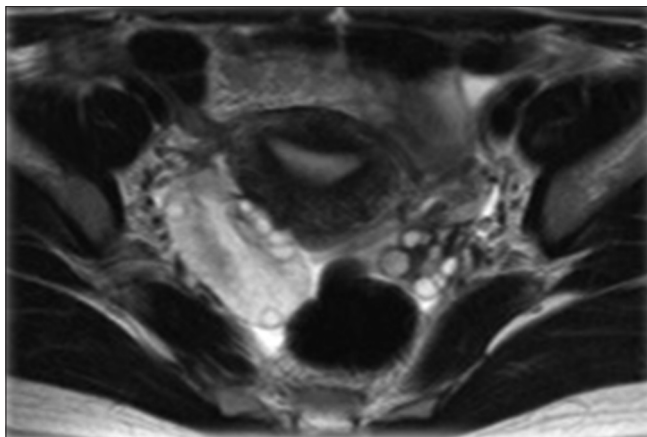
Magnetic resonance imaging image before operation; T2-weighted, coronal section image. Right ovarian edema was massive
